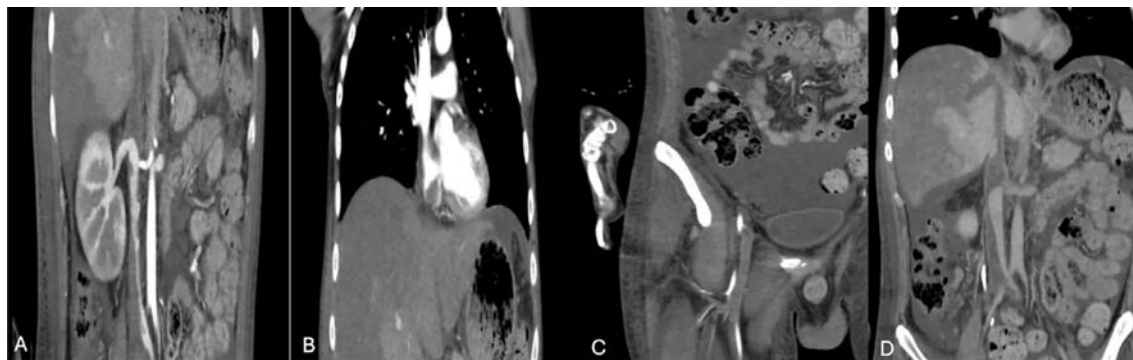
Contrast-enhanced computed tomography angiography obtained 17 days after thrombosis was first detected on Doppler ultrasonography. (A) Extensive hypodense intraluminal filling defect occupying the infrahepatic inferior vena cava, consistent with complete occlusion. (B) Cranial extension of the thrombus through the intrahepatic inferior vena cava to the cavo-atrial junction and right atrium, with heterogeneous enhancement of the enlarged liver. (C) Bilateral common and external iliac vein occlusion with diffuse circumferential venous wall thickening of the femoral veins, in keeping with vasculitic involvement. (D) Hepatomegaly with heterogeneous, patchy hepatic parenchymal enhancement and perihepatic ascites, the parenchymal correlate of hepatic venous outflow obstruction.
